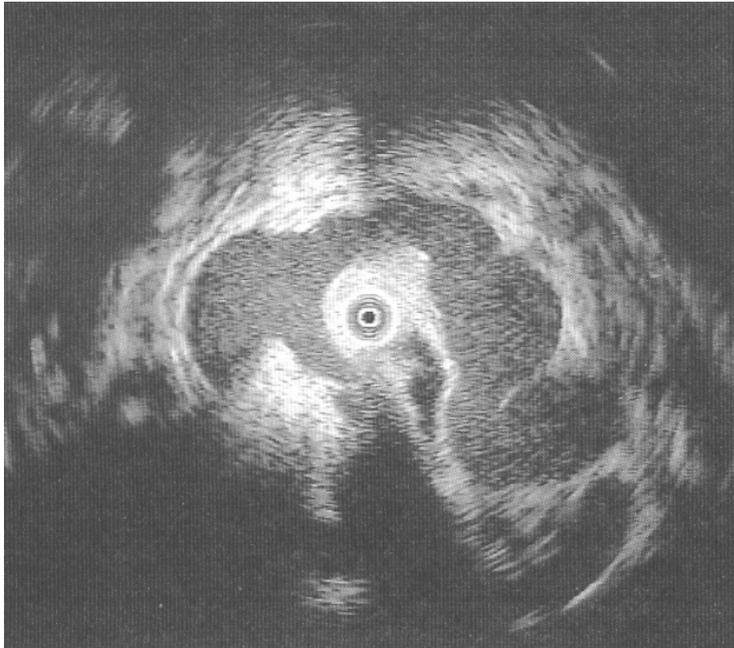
Intraluminal ultrasonography within the common bile duct showing venous collaterals adjacent to the bile duct wall.
